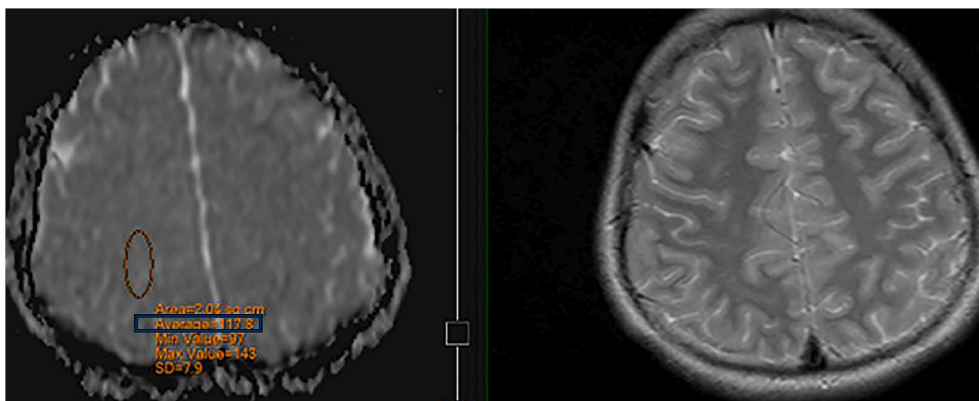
In the same patient, the ROI was positioned on the contralateral normal-appearing parietal white matter on the ADC map. A T2-weighted image was used as a reference to avoid signal contamination or interference caused by interstitial edema associated with hydrocephalus.
